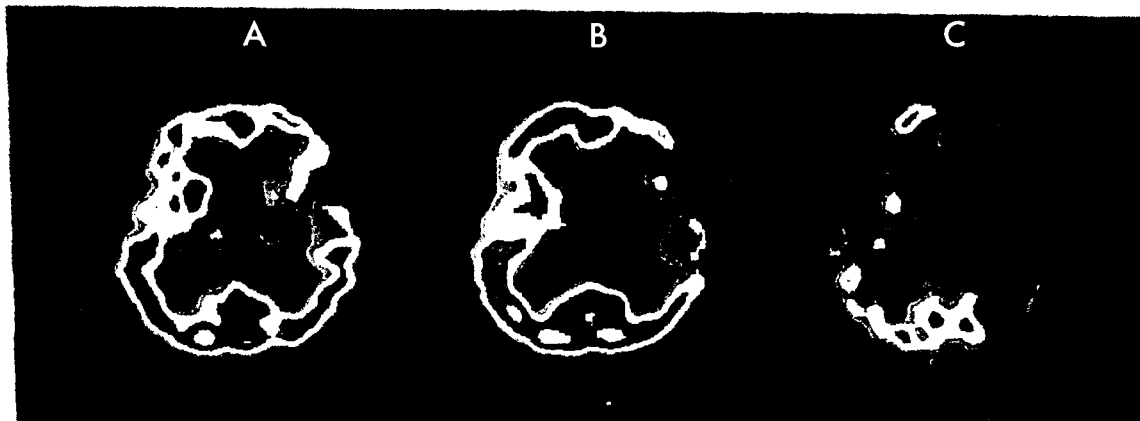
An example of consecutive clinical brain[$Tc-99m$]SPECT reconstructed images pre-(A), post-(B) Diamox, and 150% subtracted (C) of pre- from post-Diamox administration. Data acquisition parameters were 128×128 matrix, 1.4 magnification factor, 3.2 mm pixel size, 90 angular views, and 20% [$Tc-99m$] energy windows. Filtered back projection with a Hamming filter at a cutoff frequency of 0.09 cycles/mm was used for the reconstruction.
